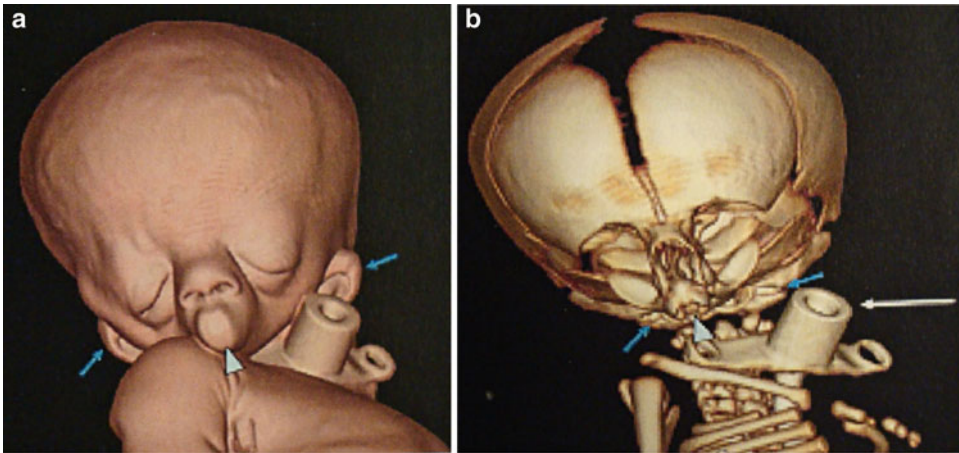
(a, b) Postmortem CT scan demonstrated mandibular agnathia with synotia (posterior rotation with ventromedial displacement of the external ear structures
